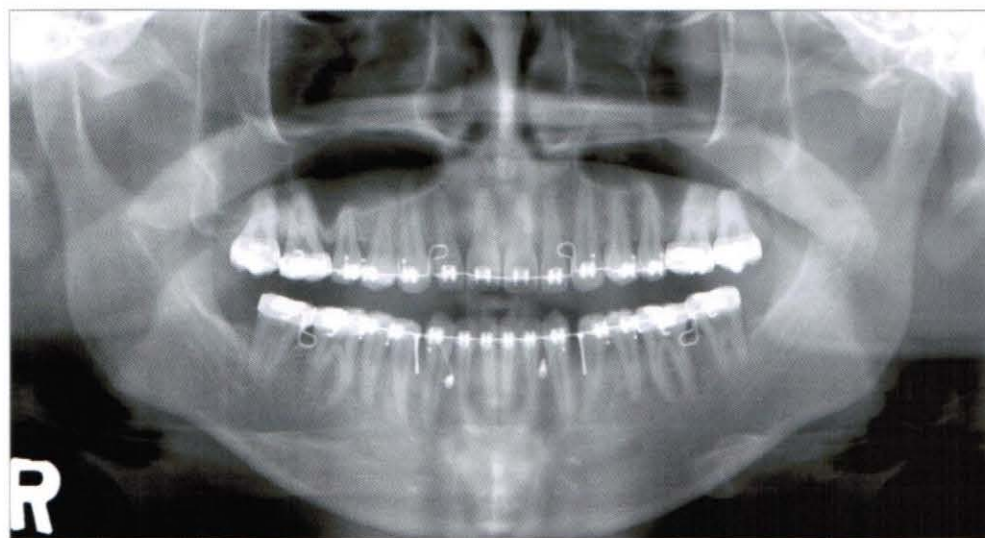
Presurgical panoramic radiograph
